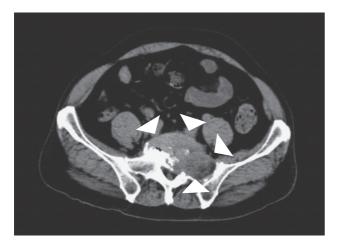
Plain computed tomography findings of sacral anaplastic thyroid carcinoma metastasis.
